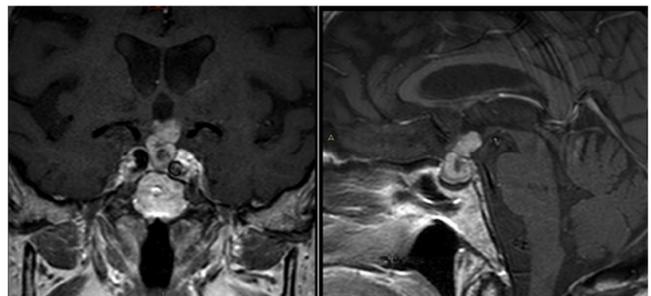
Preoperative MRI coronal and sagittal views showing the mixed signal intensities sellar and suprasellar craniopharyngioma.
